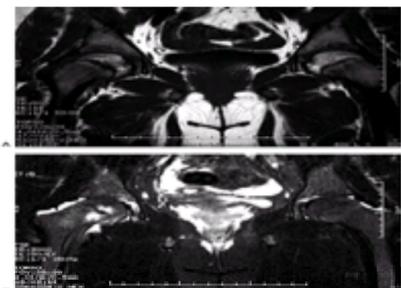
Magnetic resonance imaging (MRI) of a 12-year, 8-month-old girl with recent onset of right hip pain and a physical examination indicative of a slipped capital femoral epiphysis. A: T1-weighted image demonstrates physeal widening and minimal epiphyseal displacement on the right. B: T2-weighted image demonstrates marrow edema in the juxtaphyseal femoral neck metaphysis and femoral epiphysis, as well as a joint effusion on the right.
